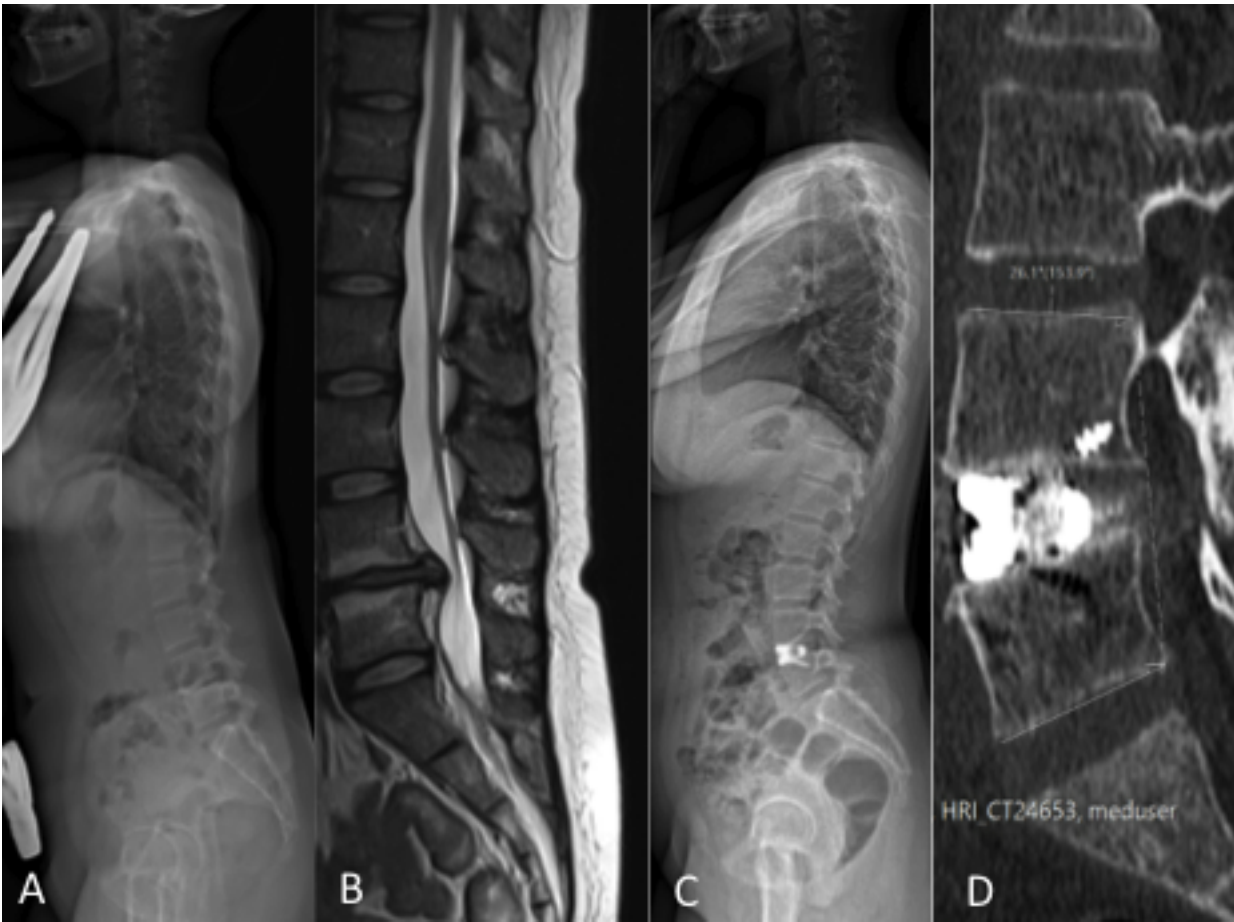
A. Pre-operative Full standing spine X-Rays-EOS showing sagittal imbalance and loss of lumbar lordosis with L4-L5 segmental Kyphosis. B. Preoperative sagittal T2 weighted image T2 showing L4-L5 discopathy (Pfirrmann 4) and disc herniation. C. Postoperative Full standing spine X-Rays-EOS showing L4-L5 ALIF with postoperative restoration of sagittal balance. D. Sagittal CT scan showing the correct positioning of the cage and L4-L5 segmental lordosis restoration.
